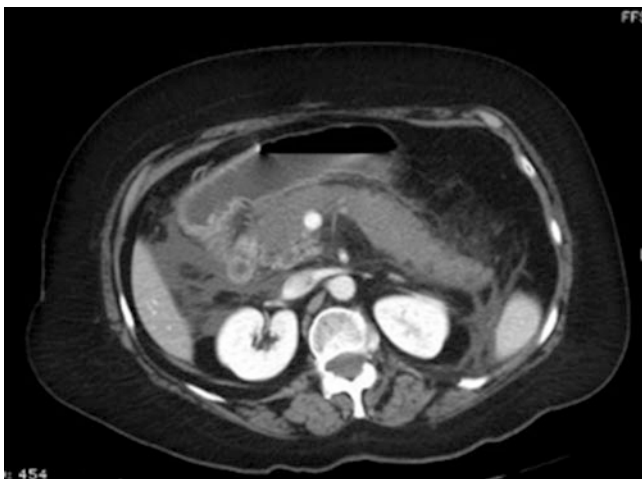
Dynamic contrast CT scan depicting no enhancement of the pancreatic parenchyma consistent with sterile pancreatic necrosis
